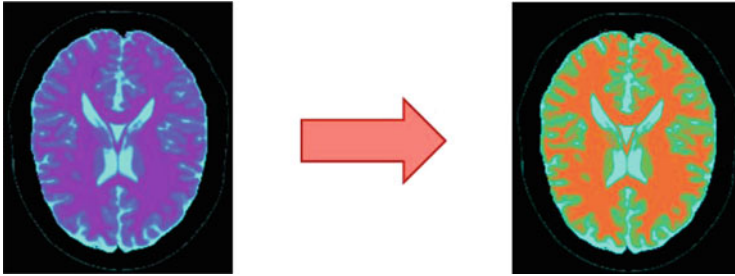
The original eight bit MRI data in pseudo-RGB (*left*) transformed into a perceptually enhanced image (*right*)
